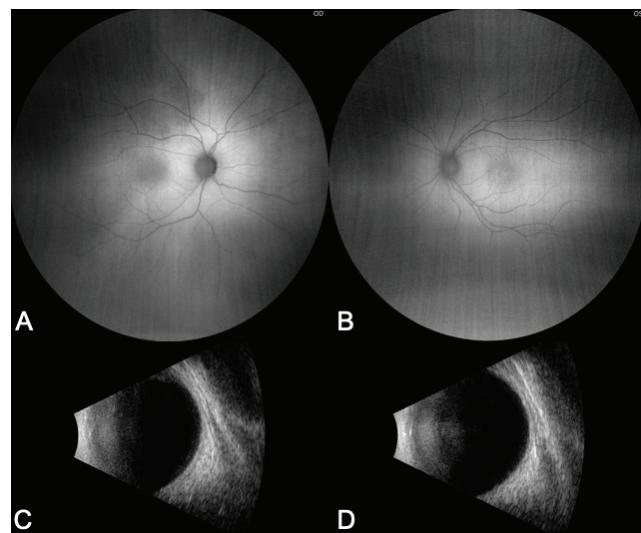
Fundus autofluorescence showing mild peripapillary hyperautofluorescence in the depigmented areas of the right eye compared to the left (A). By B-scan ultrasonography there was no mass in either eye (B).
